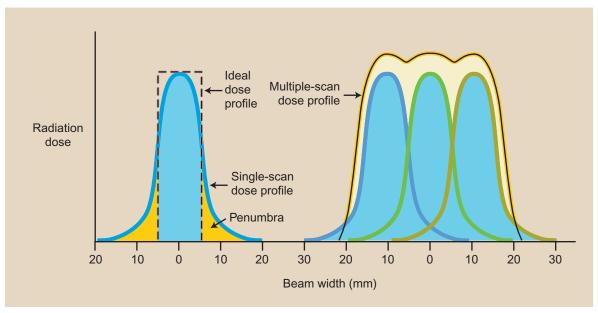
Patient dose distribution in step-and-shoot multislice spiral computed tomography is complicated because the profile of the x-ray beam cannot be made sharp.
